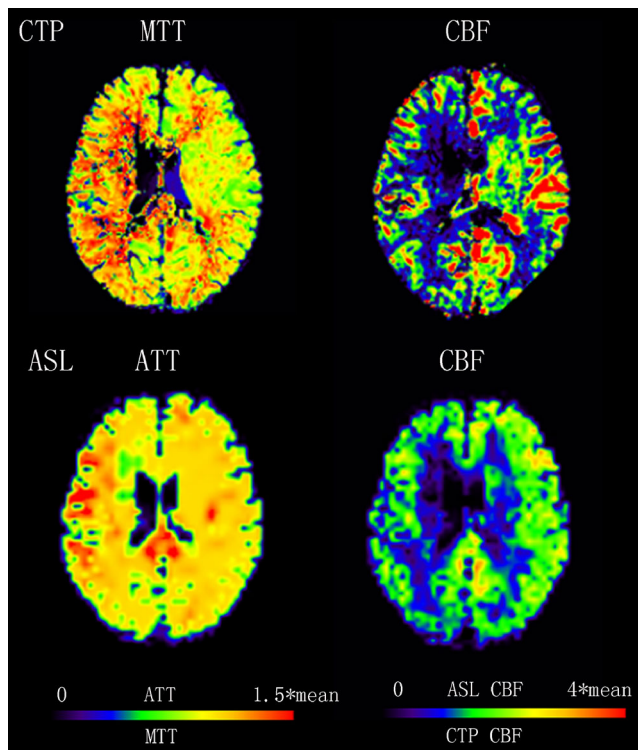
Representative case of moyamoya disease with multi-parametric CTP and ASL images. A 24-year-old male patient with 6 months of transient headache and weakness in the left limb. The time interval between preoperative CT perfusion and pCASL was 1 day. CTP shows low perfusion areas in the right temporal-parietal lobe with decreased CBF values and elevated MTT. ASL is in concordance with the result of CTP
